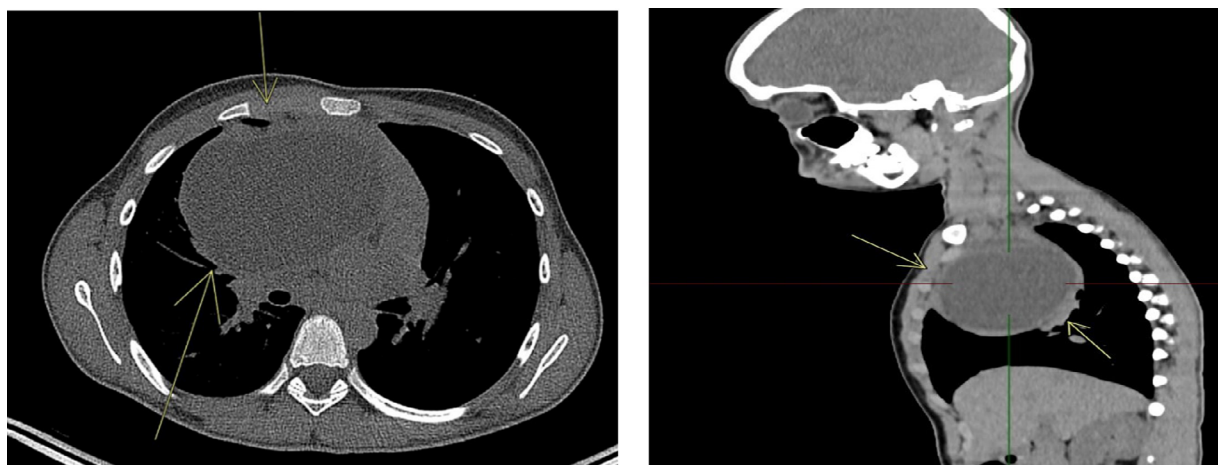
PET/CT. A. PET/CT. A. Axial section where the arrow shows a single polylobulated mass measuring 7.3 x 11.3 x 16.6 cm. B. Sagittal view showing with the arrow a single polylobed mass measuring 7.3 x 11.3 x 16.6 cm.
